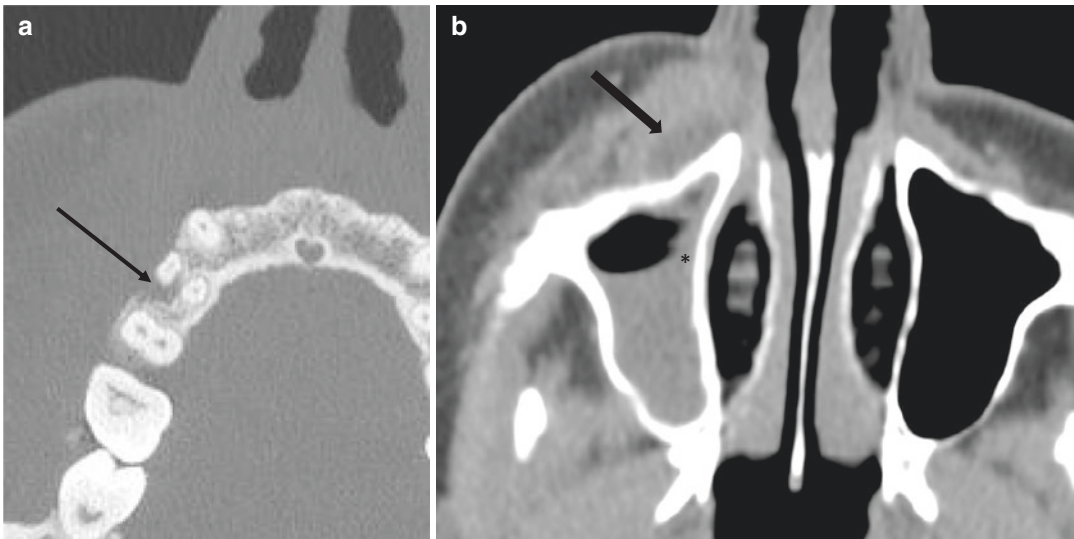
(a) Axial CT mandible bone window showing periapical lucency surrounding the buccal root of the right upper fourth tooth as well as buccal cortical erosion (black arrow). (b) Axial CECT soft tissue window showing
